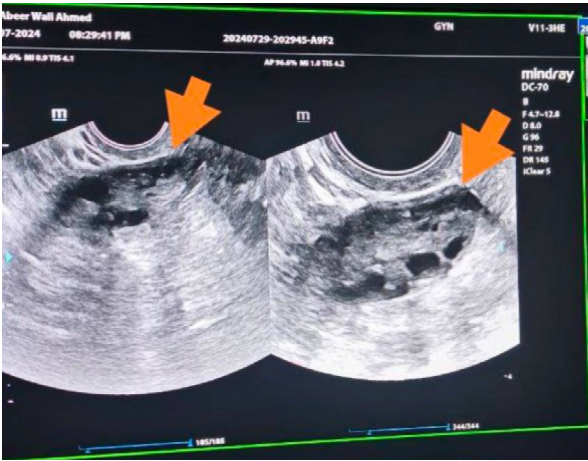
Transvaginal ultrasound image shows bilaterally enlarged ovaries with a borderline size, multiple small follicles, more than 10 in number, are located peripherally
